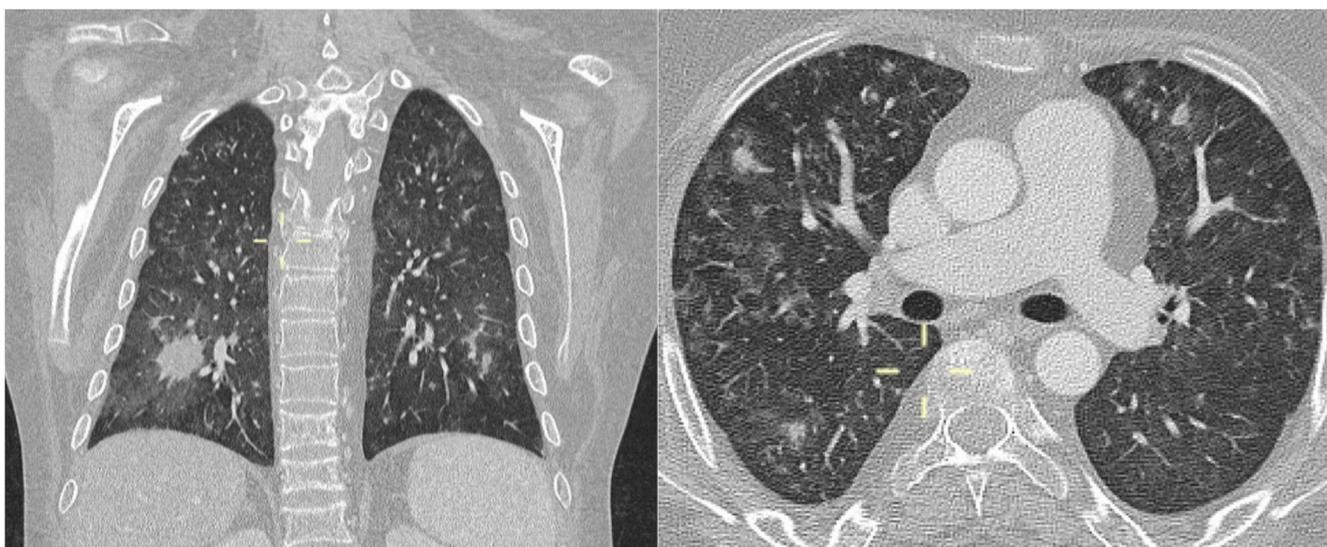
Coronal and axial MPR CT reconstitution (patient 1)—diffuse ground-glass opacities with nodules due to alveolitis with intra-alveolar fibrin and debris. In the coronal view, a definite nodule is evident in the lower right lobe, with ground-glass opacities around the nodule.
